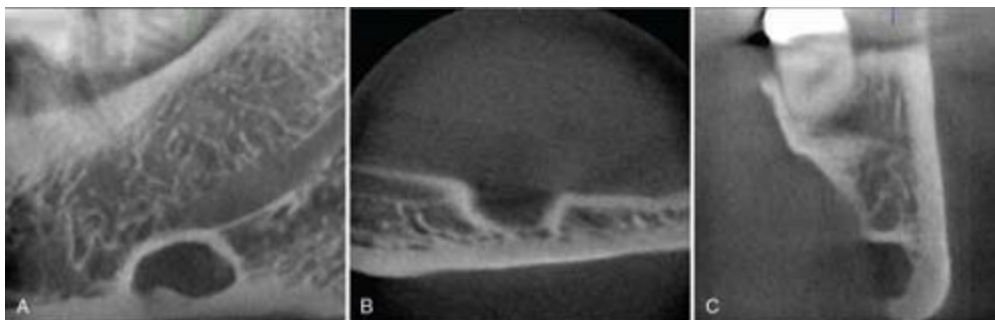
Stafne defect. A, Sagittal CBCT image showing a well-defined loss of density inferior to the mandibular canal. B, Axial CBCT image demonstrating a lingual concavity. C, Coronal CBCT image also exhibiting a lingual concavity inferior to the mandibular canal with no involvement of the root ends.
